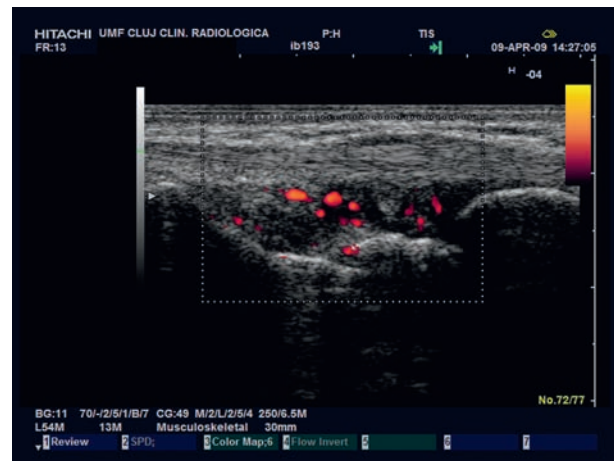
Power Doppler US: F, 35 years, proliferated synovial vascularity in the right ulnocarpal joint, score 2
